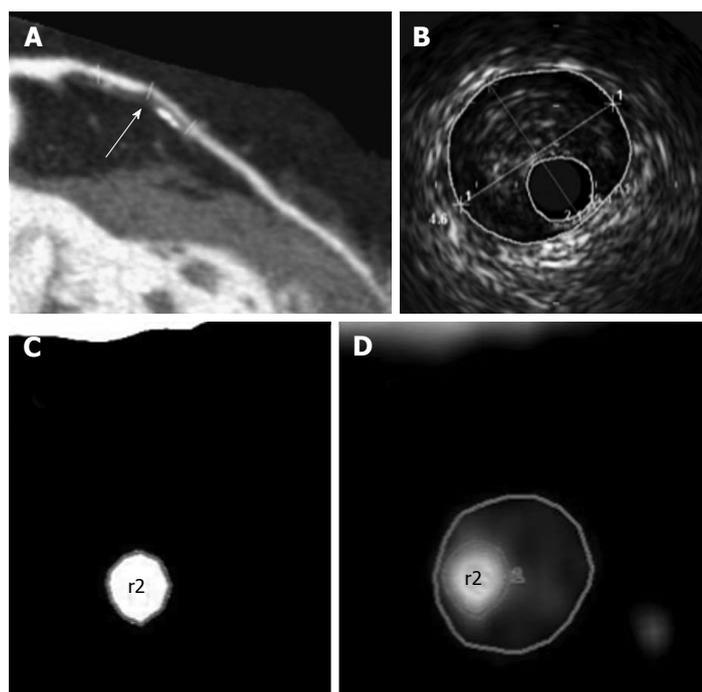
The window settings for the lumen and outer vessel boundary by computed tomography angiography are the same as those for intravascular ultrasound imaging^[19]. A: A curved multiplanar reconstructed CTA image reveals a significant stenosis in the left anterior descending artery (arrow); B: An IVUS cross-section reveals a lumen area of 2.1 mm² and a vessel area of 15.4 mm²; C: The cross-sectional CTA images show the luminal CSA of 2.1 mm²; D: Vessel CSA of 15.4 mm². CTA: Computed tomography angiography; IVUS: Intravascular ultrasound; CSA: Cross-sectional area.
